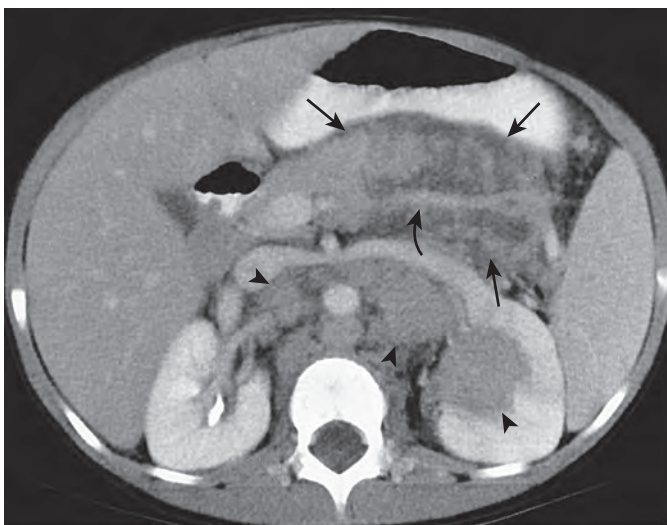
Lymphoma infiltrating the pancreas. The CT scan shows enlargement of the pancreas with infiltration by nodular soft tissue representing nodal enlargement (straight arrows) in a 7-year-old boy with Hodgkin's lymphoma. Notice the blood vessel (curved arrow) coursing through this region and the retroperitoneal adenopathy extending into the left renal hilum (arrowheads).
